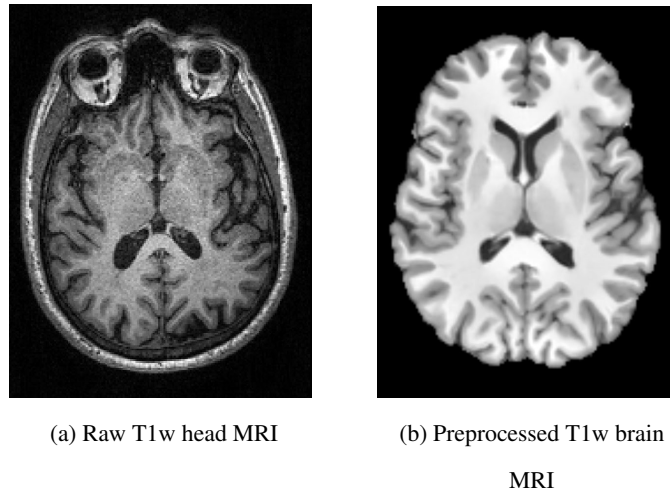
(a) Axial slice of raw T1w MRI and (b) preprocessed T1w MRI with bias field correction, skull stripping, intensity normalization, registration to ICBM 152 brain template of (a).
